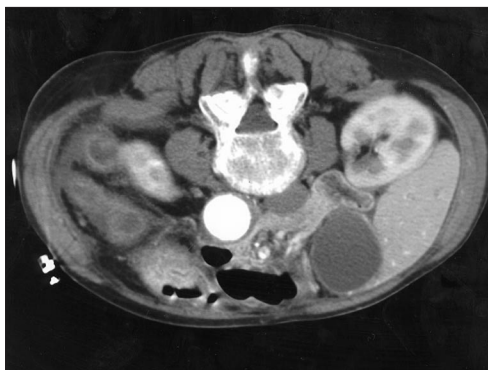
Computed tomography scan showing the abrupt cut-off of contrast in the superior mesenteric artery.
